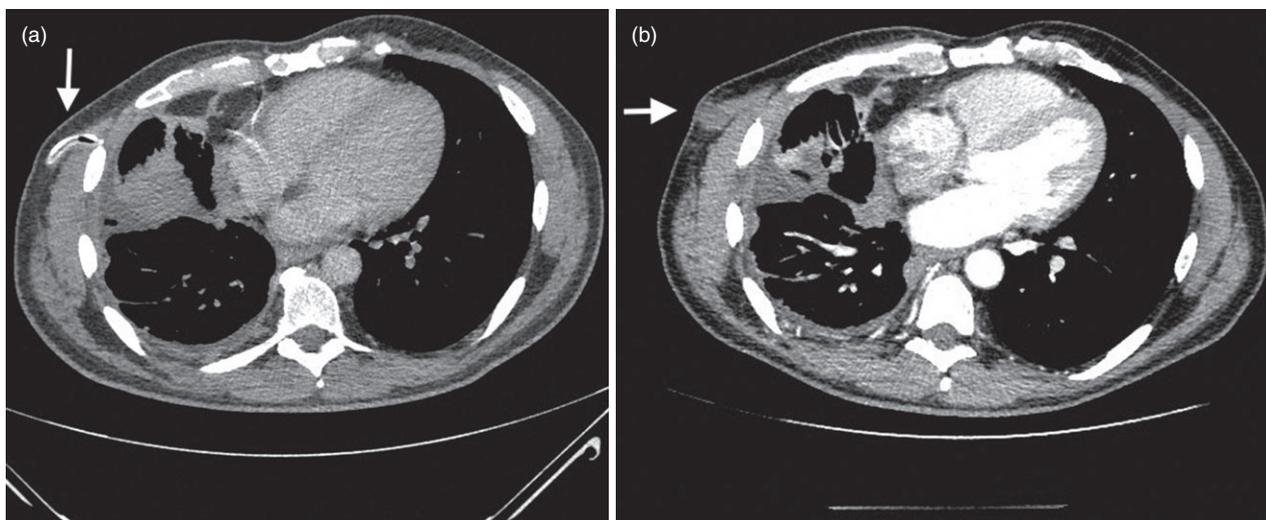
(a) Computed tomography (CT) thorax (axial view) showing right-sided indwelling pleural catheter *in situ* (arrow), which was later removed after spontaneous pleurodesis, in a patient with malignant mesothelioma. (b) CT thorax shows subcutaneous growth along the previous catheter tract (arrow), confirmed by fine needle aspiration cytology to be malignant tract metastasis.
